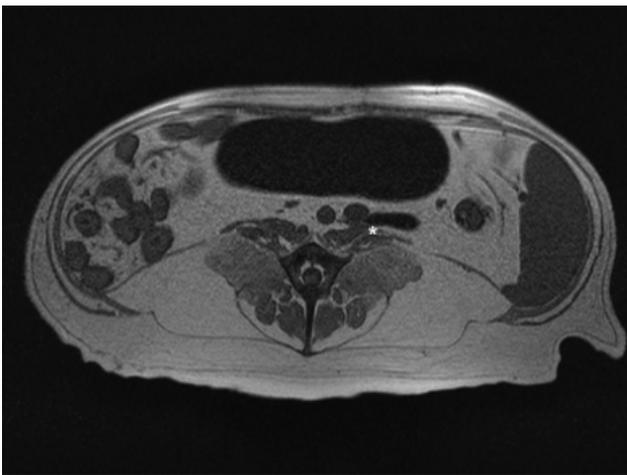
T1-weighted transverse gradient-echo sequence (TR = 166 ms, TE = 7.49 ms, flip angle 70°) centered in the area of the ureteral dilation confirms the occlusion of the left ureter between the dorsal wall of the caudal vena cava and the ventral surface of the psoas muscles (white star). Right is to the left and ventral is to the top.
